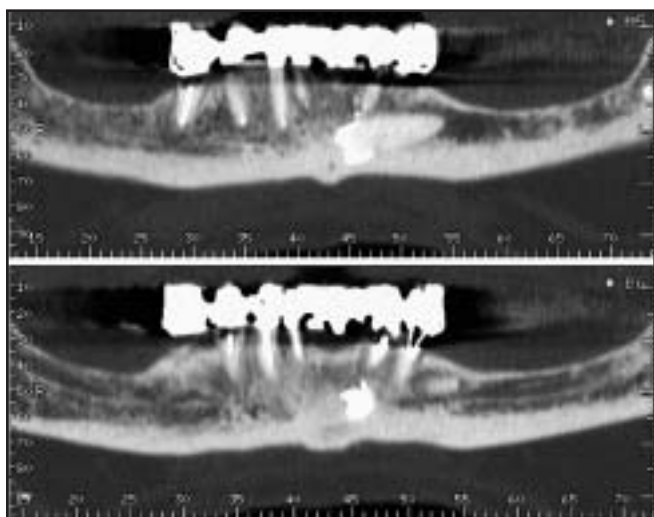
Patient 3. Panoramic sections of a computed tomographic (CT) scan showing the orientation of the impacted premolar.
